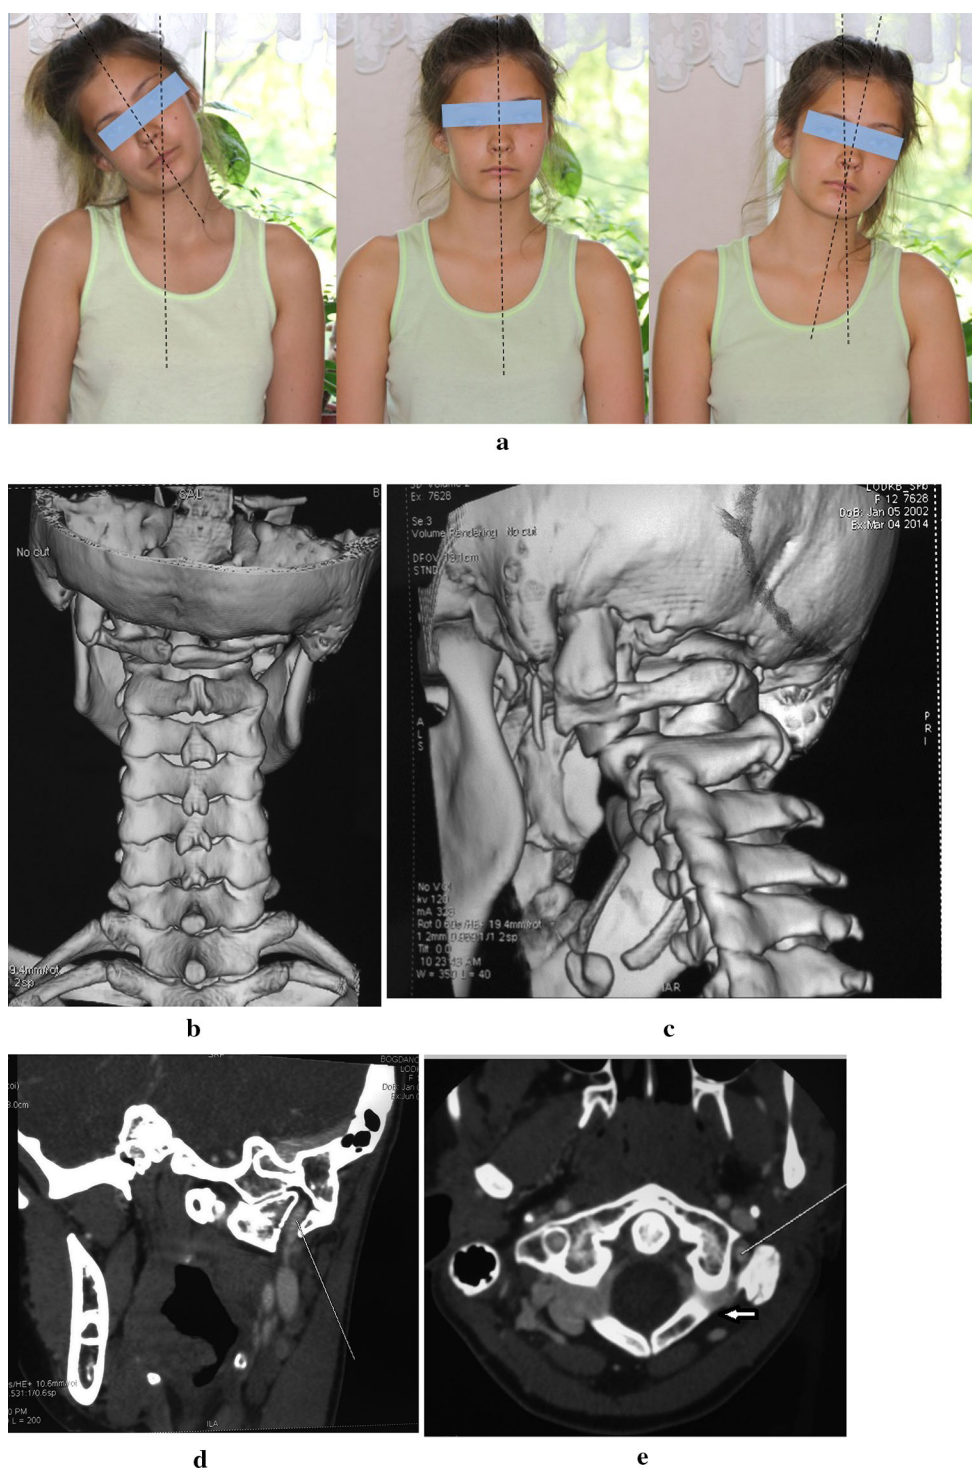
Pre-op frontal photo-series (a), 3D-CT (b, c), and frontal (d) and axial (e) angio-CT scans of the 12-year-old girl (case no. 3). The pre-operative frontal plane maximal range of motion (ROM) is estimated as 42°d—0°—18°s. The additional bone is close to the vertebral artery
